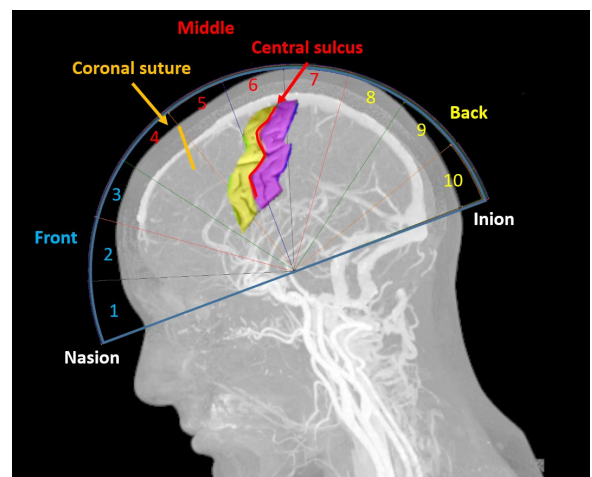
CT scan with the cerebral cortex divided in 10 segments
